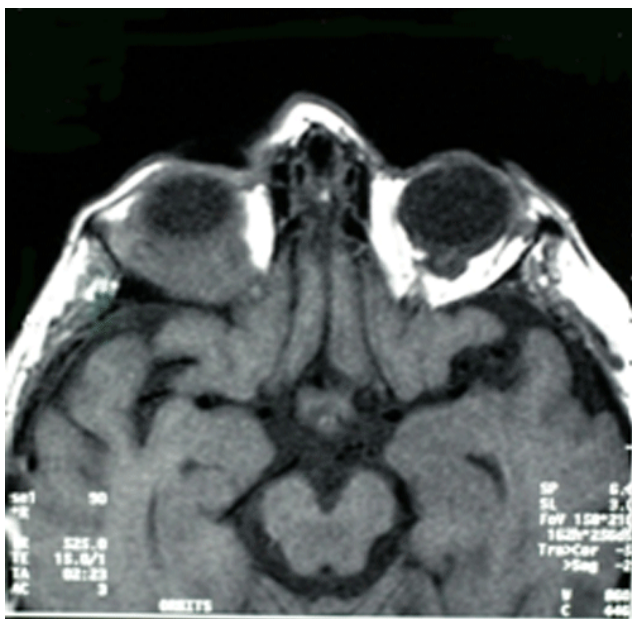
Coronal T1 MRI of skull shows intra- and extra-conal soft tissue signal intensity lesion encroaching upon right optic nerve, likely infiltrating and effacing retrobulbar fat
